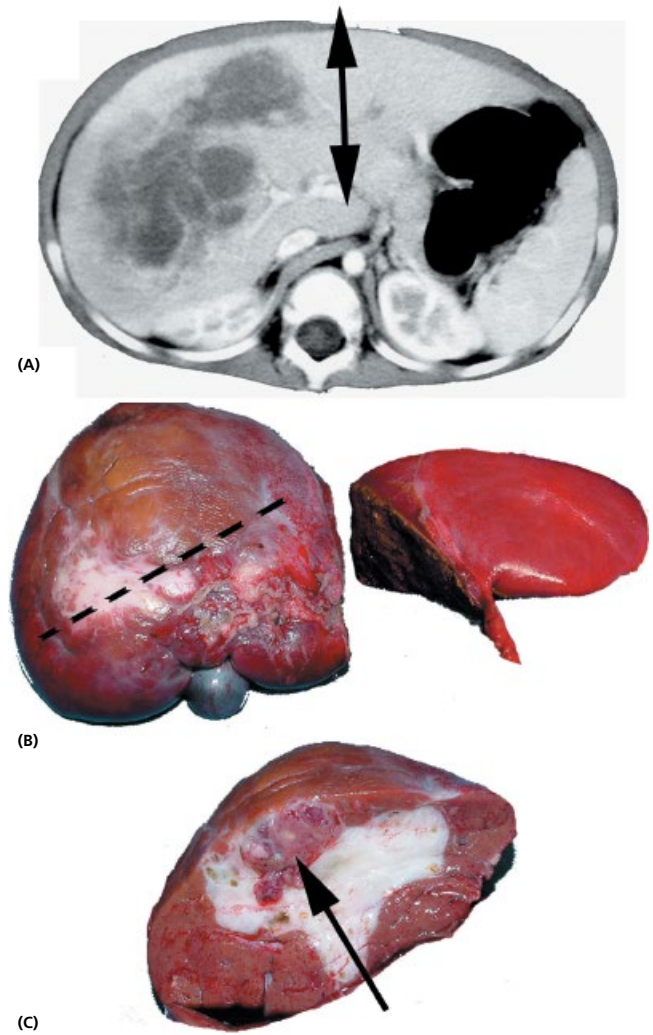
Extended right hepatectomy for large hepatoblastoma. (A) Preoperative CT scan showing the tumor location and extension from the right liver toward the left. The arrow indicates the liver resection line. (B) Intraoperative view showing the resected liver (left side) and the remaining healthy parenchyma (right side). (C) Macroscopic appearance of the tumor at section (resection along the dotted line shown in B). The large white areas represent fibrotic and necrotic transformation of the tumor, but a viable node is still visible (arrow).
